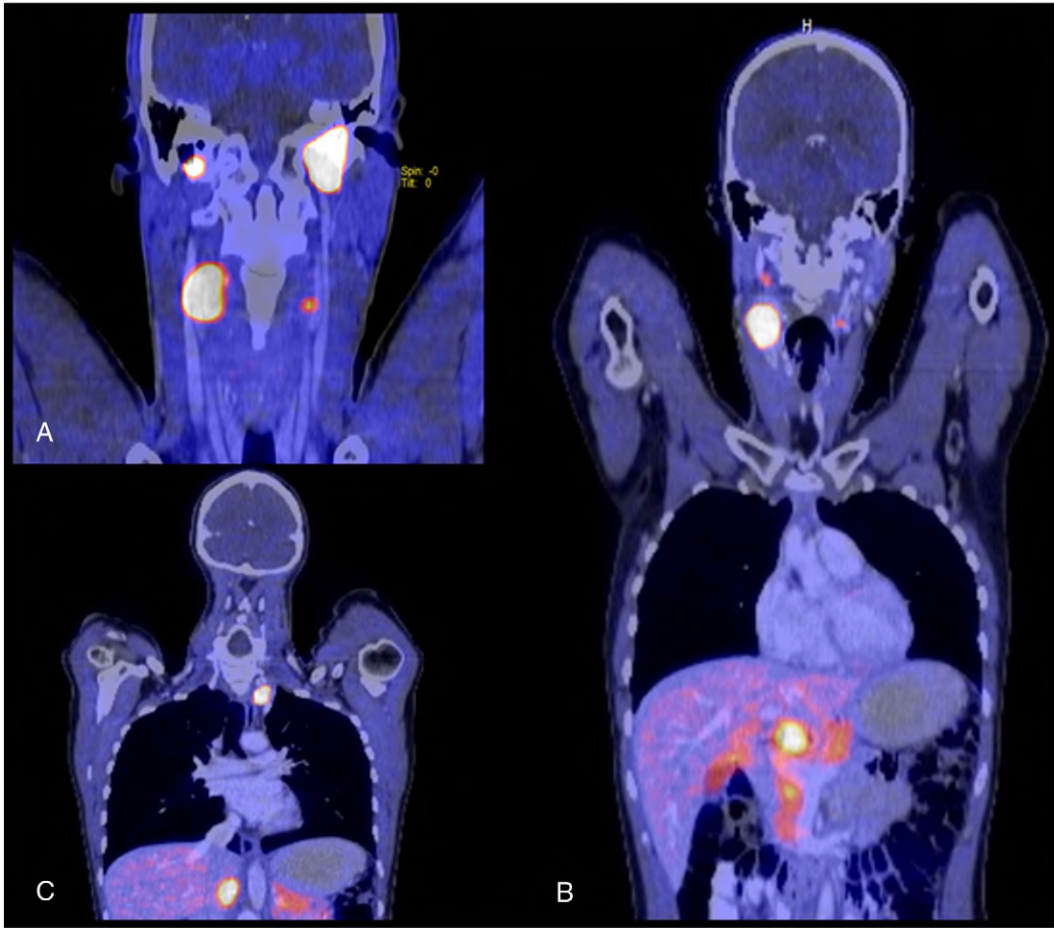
(A) Patient 6: ¹⁸F-DOPA PET/CT, showing bilateral jugulotympanic and carotid paragangliomas with contrast enhancement and ¹⁸F-DOPA uptake. °(B) Patient 7: ¹⁸F-DOPA PET/CT, showing bilateral carotid paragangliomas (right > left) and one vagal paraganglioma on the right side with contrast enhancement and ¹⁸F-DOPA uptake. °(C) Patient 7: ¹⁸F-DOPA PET/CT, showing a paraganglioma in the left upper mediastinum and in the hilum of the liver.
